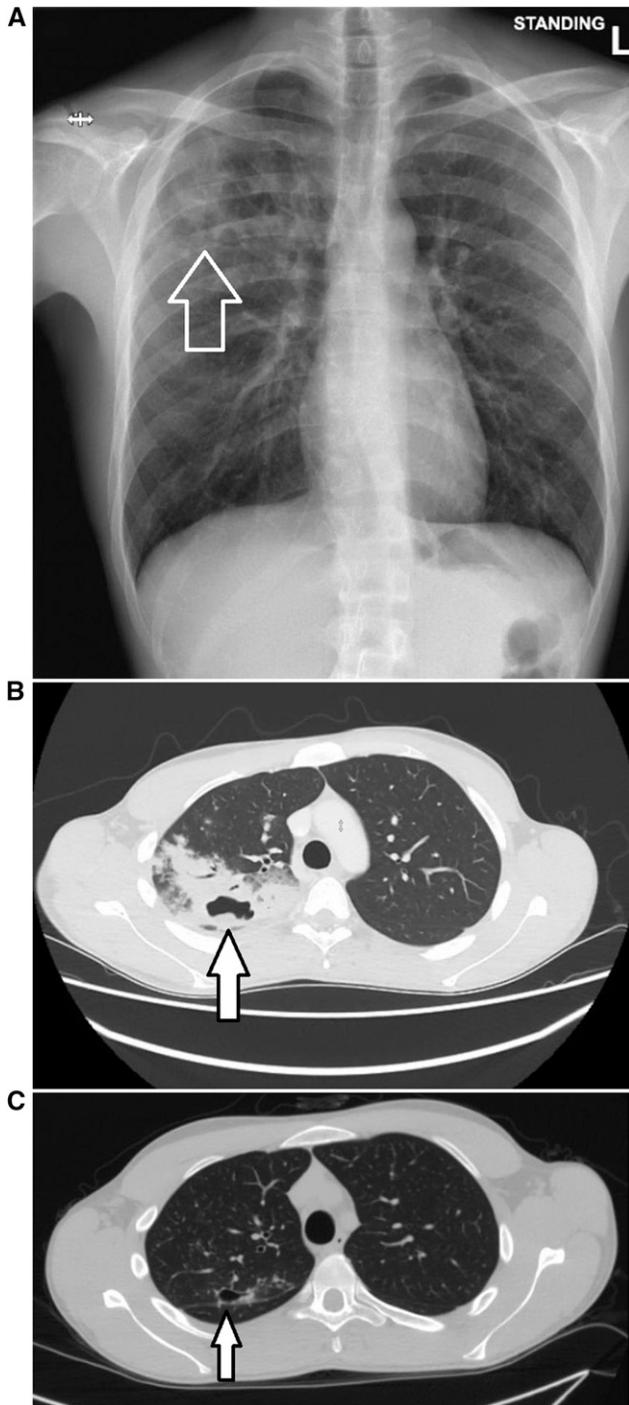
(A) Chest X-ray showing infiltration and cavitation in the right upper lobe, (B) chest CT scan showing cavitary lesion at the right upper lobe, and (C) CT scan at the end of treatment showing near resolution of findings. Arrows point major radiographic findings (A–C).
